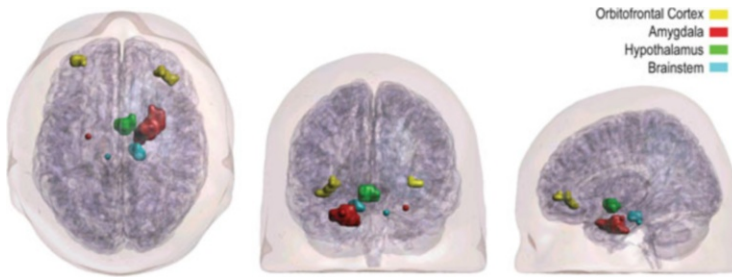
Three-dimensional rendering of the skin and the brain from a T1-weighted magnetic resonance imaging scan (*top, frontal and left* views, respectively). Clusters of suprathreshold activity in response to angry versus happy facial expressions during the first session in the main regions of interest are color-coded
